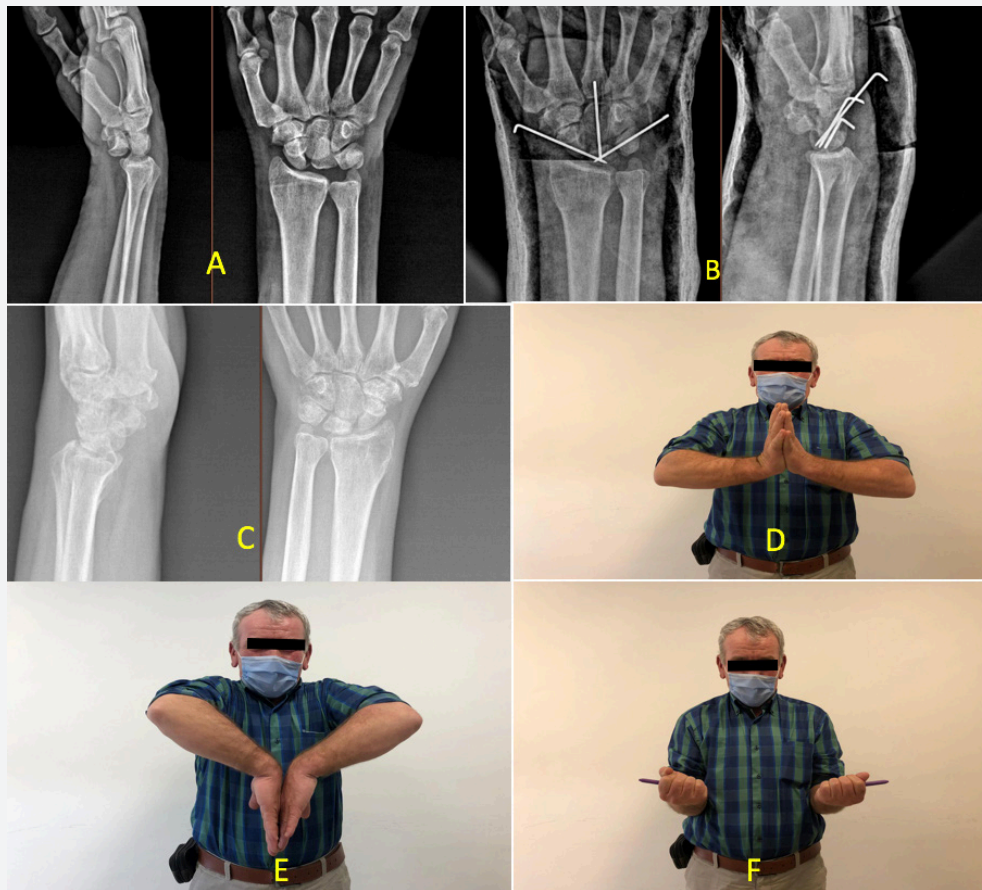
X-rays and functional results of the isolated perilunate dislocation case. A) Perilunate dislocation preoperative X-ray images, B) Fixation with scapholunate, lunotriquetral and capitulunate K-wires, C) Postoperative 3rd year X-ray images, D) Follow-up wrist joint dorsiflexion of the case, E) Follow-up wrist joint volar flexion of the case, F) Follow-up wrist joint rotation of the case
